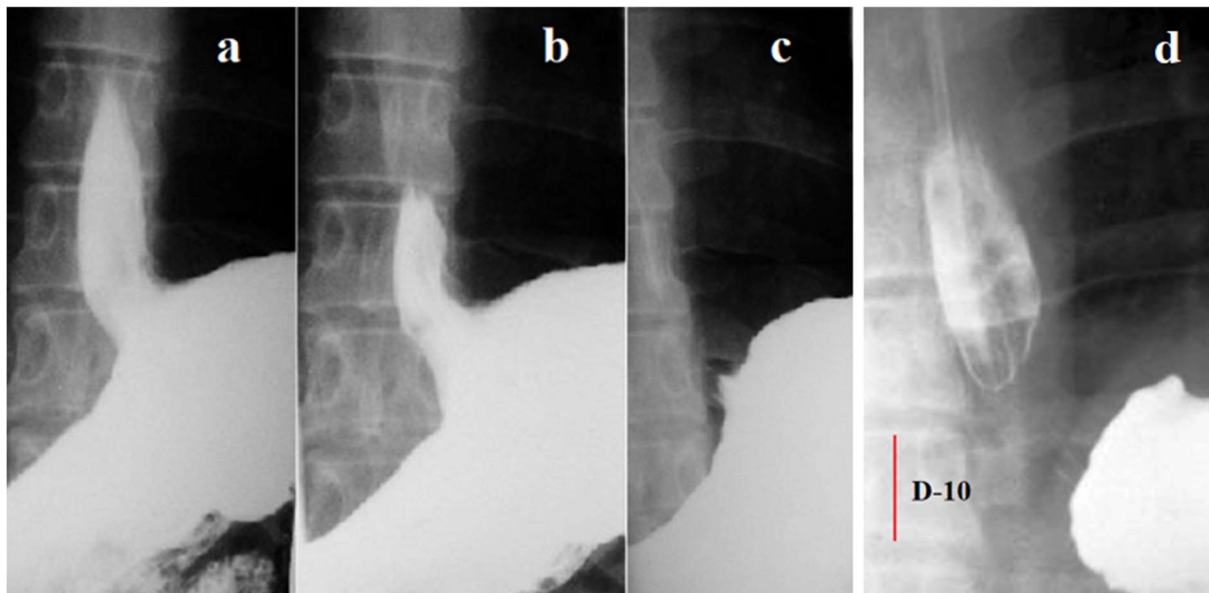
The passage of the bolus through the EGJ during abdominal compression in the horizontal position of patients. (a,b,c). In a patient without GERD symptoms, the peristaltic wave overcame the increased tone of the LES, because of which barium passed into the stomach without delay. (d). In a patient with GERD, as evidenced by longitudinal folds in the esophagus and at the level of the LES, abdominal compression resulted in LES contraction. Its length can be measured between as the X-ray negative distance between the esophagus and the stomach. Since the height of D-10 is approximately 2 cm, the true length of the LES can be calculated. It is equal to 2.4 cm.
